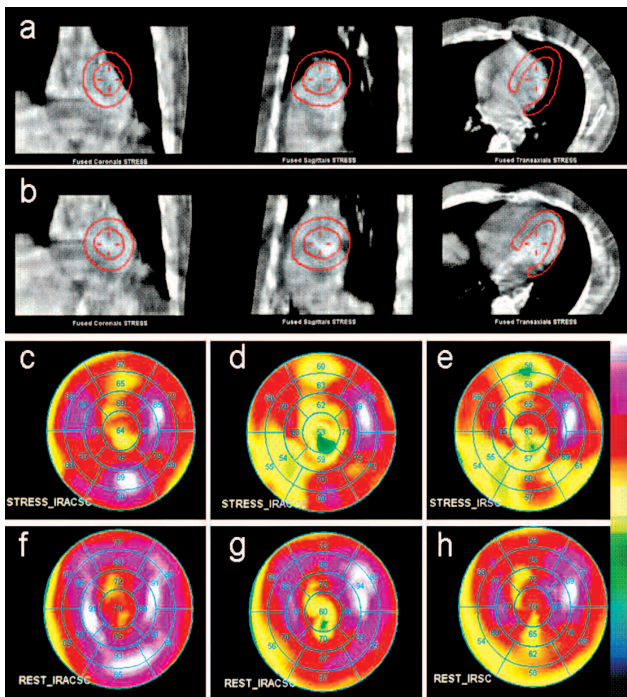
The stress study of a male patient is displayed (a-e) with the same image arrangement as in figure 7. The maximum CT shifts needed for registration restoration was 0.62 pixels to the cranial direction and the sum of shifts in all directions was 0.79 pixels. Despite the mild registration error (a), significant differences between the misregistered (c) and reregistered (d) study are shown in the corresponding polar maps.
